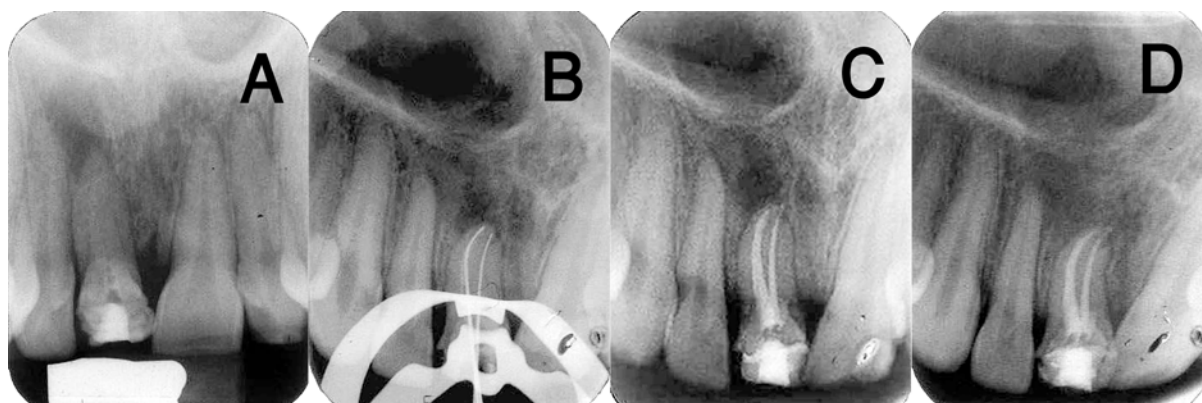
A) A pulp-otomized right central incisor. Examination of the radiograph revealed the possibility of two roots. B) The working length measurement radiograph showed two files in two separated roots. C) Postoperative radiograph, two separated roots. D) Radiograph taken at six-month recall visit, showing healing of apical pathosis
